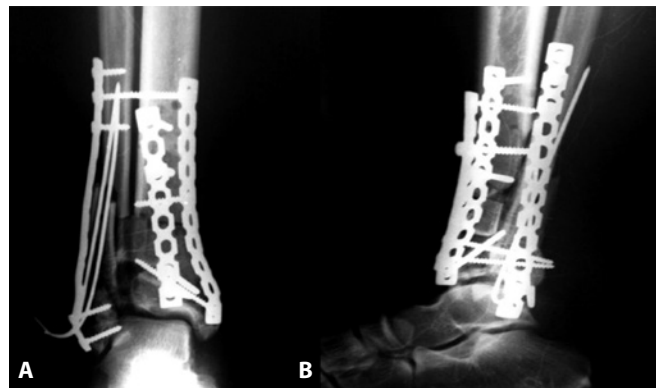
Postoperative X-ray. A. Anteroposterior. B. Lateral.
